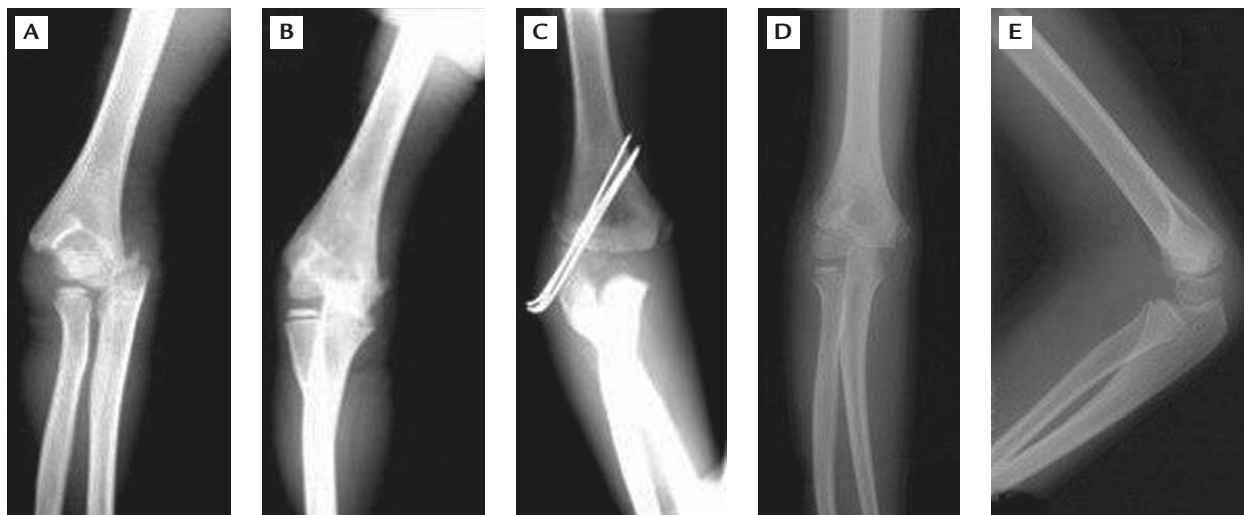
Case 1: (A, B) preoperative X-rays; (C) postoperative X-ray; (D, E) X-rays at 36 months' follow-up showed good reduction and good union, and normal elbow development was noted.
